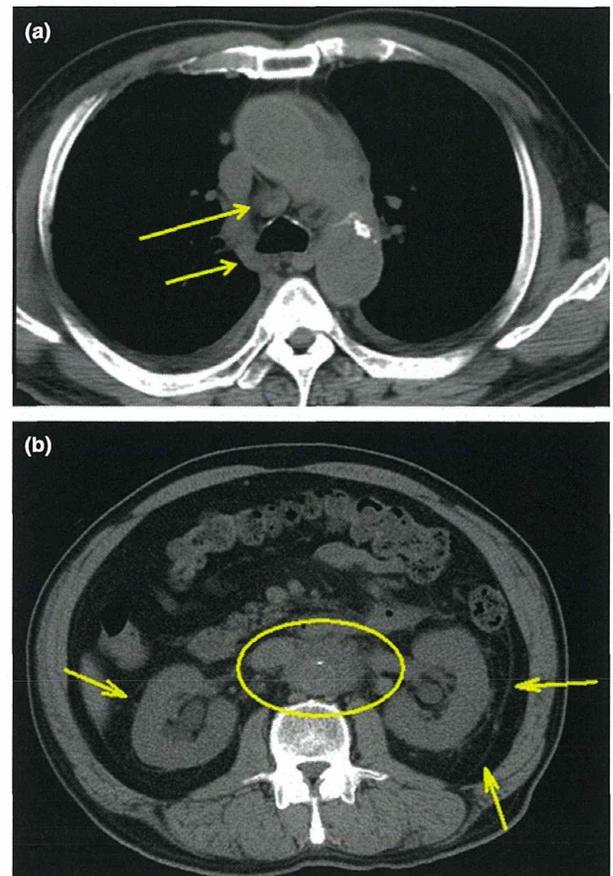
Computed tomography showed (a) mediastinal lymphadenopathy (arrows) and (b) retroperitoneal fibrosis (circle) and its secondary bilateral hydronephrosis (arrows).
